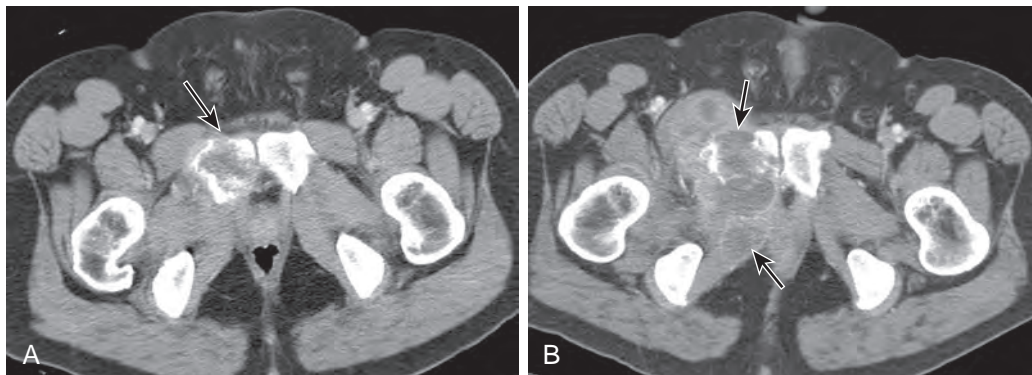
Measurement of bone lesions per RECIST 1.1. Initial (A) and follow-up (B) axial contrast-enhanced CT of the pelvis showed a lytic lesion in the right pubic bone (arrows) with significant interval increase in the soft tissue component on follow-up scan (B) consistent with progressive disease. RECIST1.1, unlike RECIST 1.0, has clear-cut guidelines on measurement of soft tissue components of bone metastases.
